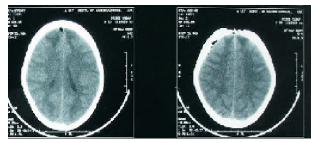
CT Head of patient showing bone defect in the frontal region
